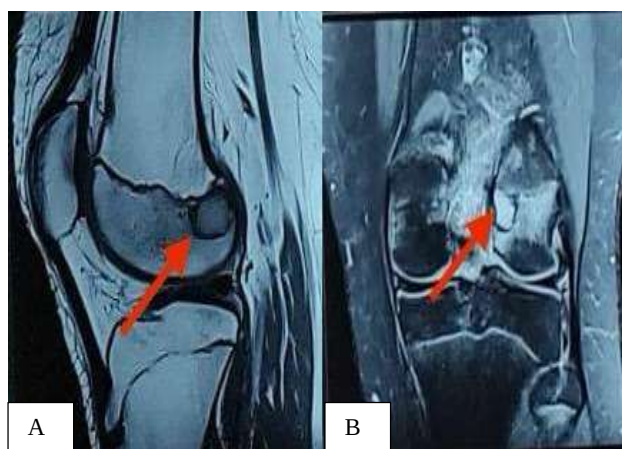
MRI of left knee showing an oval altered signal intensity area in lateral condyle of femur (1.5x1.1x1.6 CMS) at the level of attachment of ACL (Red arrow).
